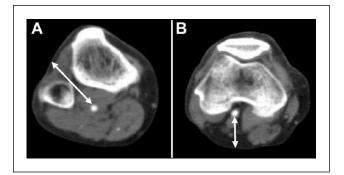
Evaluation of the depth of the popliteal artery from the body surface using computed tomography images; these images are from the right leg in the same patient. (A) The distance from the body surface of the anterolateral side of the knee through the interosseous membrane to the P3 segment. (B) The distance from the back of the knee to the P2 segment.
